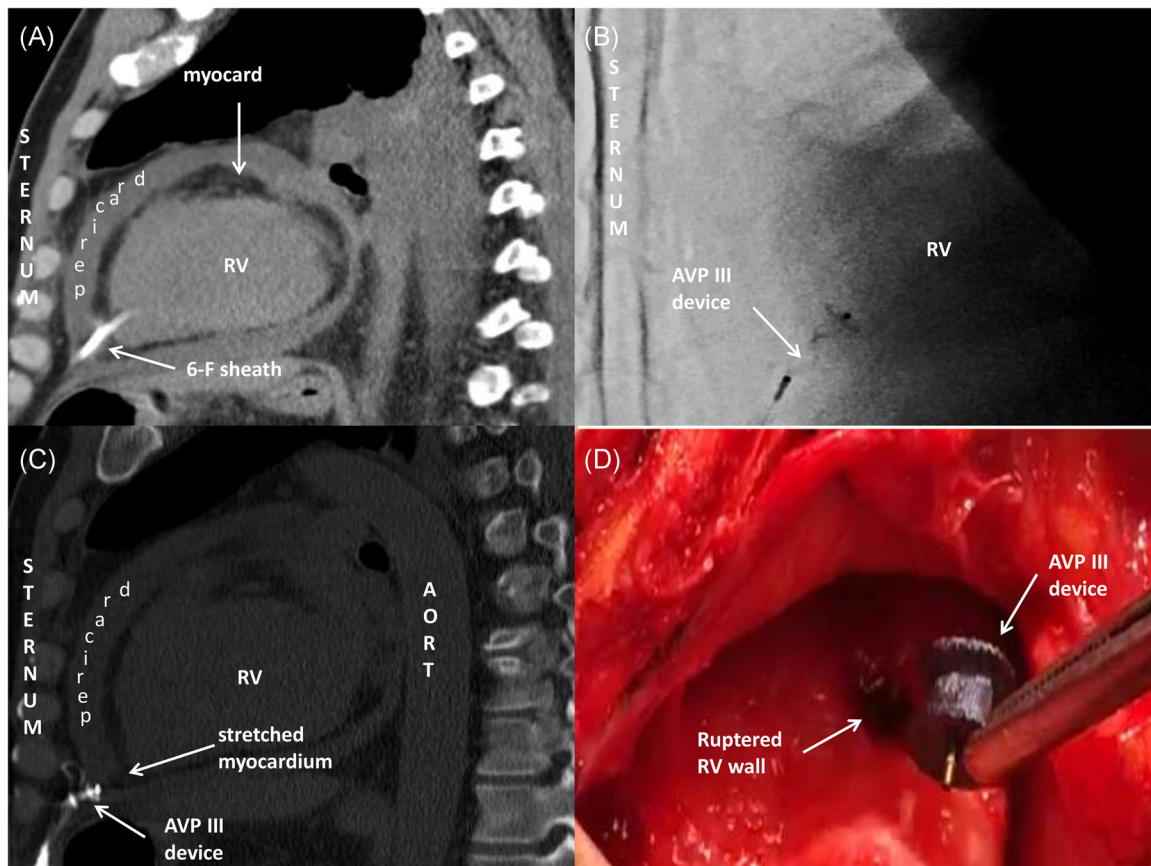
(A) Computerized tomography in the sagittal plane, showing the penetration of the 6-Fr sheath to the right ventricular (RV) myocardium. (B) 180° lateral fluoroscopic window, demonstrating the position of the Amplatzer vascular plug-III (AVP-III) device on the RV free wall. (C) Computed tomography in the sagittal plane indicating how the AVP-III device stretched the RV myocardium outwards. (D) Intraoperative imaging revealing ruptured RV free wall and dislocated AVP-III device
